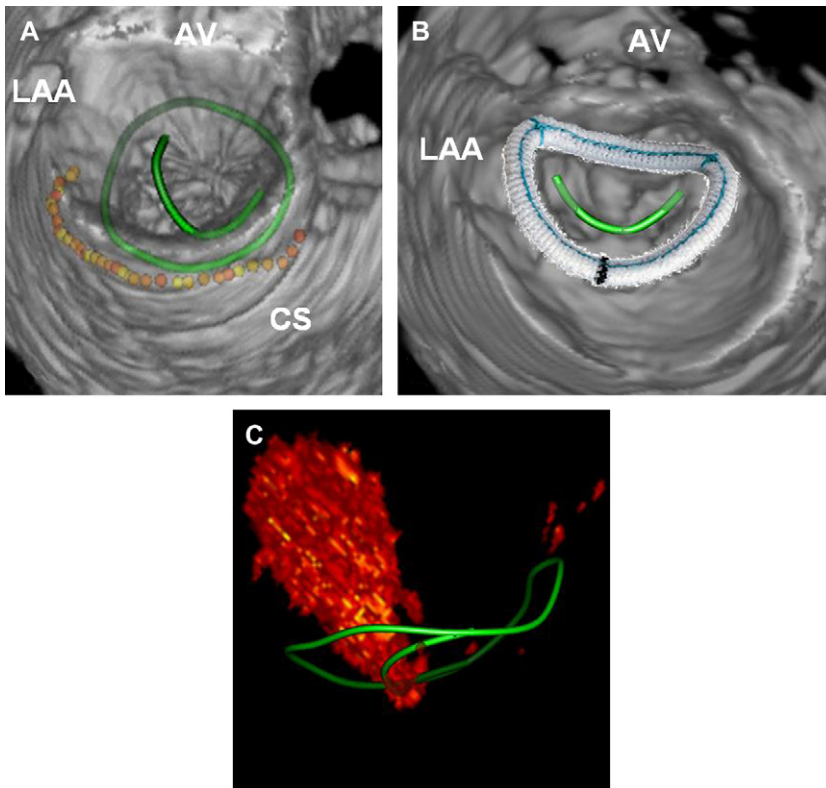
(A) The coronary sinus (CS) together with mitral valve annulus and coaptation line (4D MV-Assessment CAP, TomTec Imaging Systems, Unterschleissheim, Germany). Visualizing the ring into the volume-rendered image (B) may help to assess the correct ring size preoperatively. Future 3D color Doppler technologies may allow quantifying the regurgitation volume (C).
